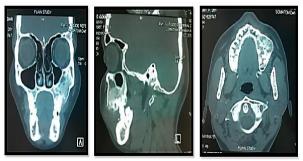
CT scan reveals ground glass appearance involving the left maxilla
